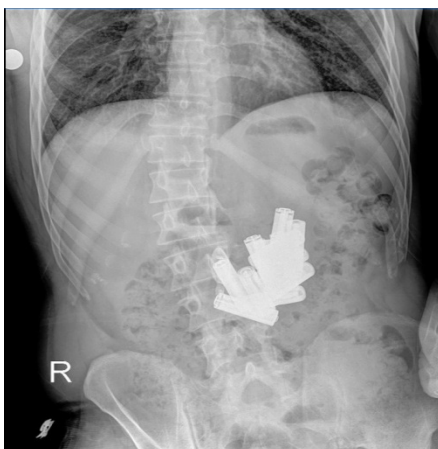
Foreign bodies displaying extensive calcification within the abdomen in ambulant direct abdomen radiography
